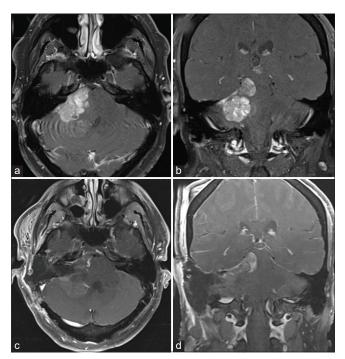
(a and b) Axial and coronal T1 postcontrast preoperative magnetic resonance imaging (MRI) before translabyrinthine craniotomy. (c and d) Axial and coronal T1 postcontrast postoperative MRI after translabyrinthine craniotomy.
